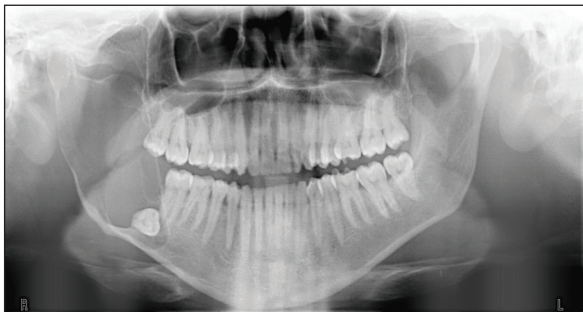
Radiographic image of unicystic ameloblastoma before decompression.
